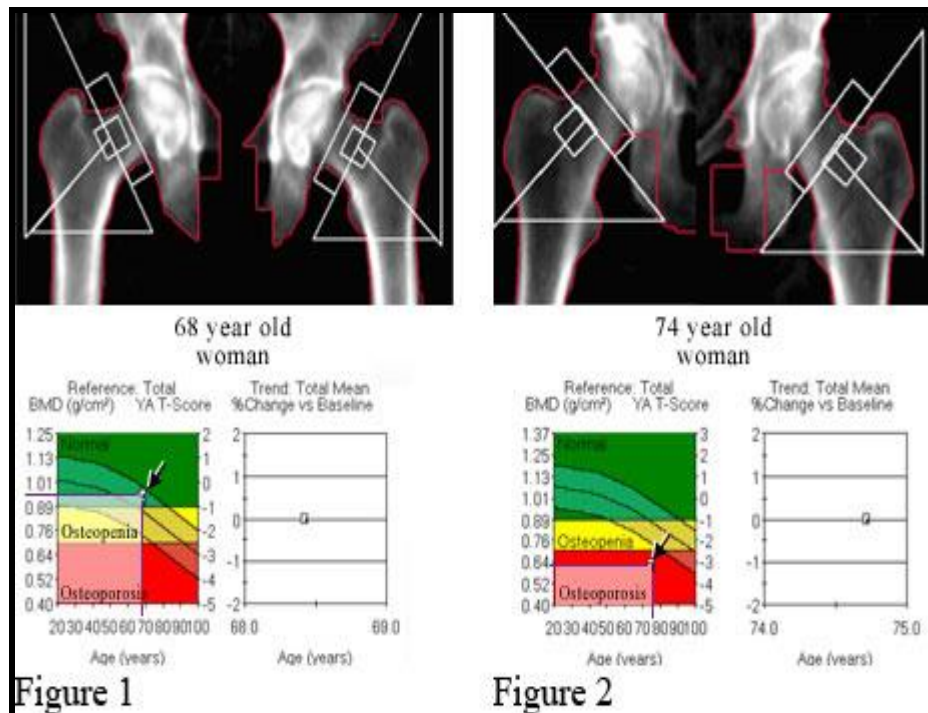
(): Shows a bone mineral density (BMD) test of a healthy older woman. The X-ray shows normal hipbones. The graph shows the bone mineral density number in the green zone (normal). Figure 2 shows a BMD test of an older woman with osteoporosis. The X-ray shows weaker hipbones. The graph shows the bone mineral density number in the red zone (osteoporosis), placing her at much greater risk for broken bones (fractures) (Carla, 2004).
